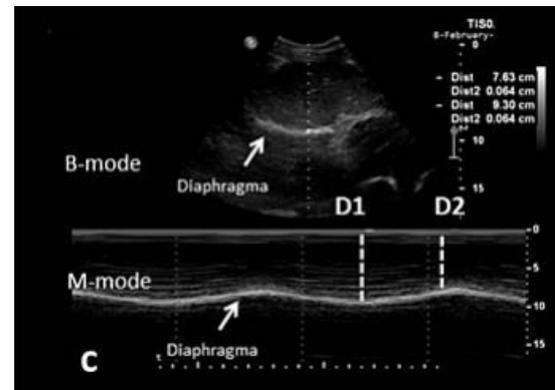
Assessment of right diaphragm excursion by Gok et al. (51), in both B- and M-mode ultrasonography using a convex probe. Here, $D1 = DE$ during inspiration and $D2 = DE$ during expiration, where the total DE is calculated as $D1-D2$.
